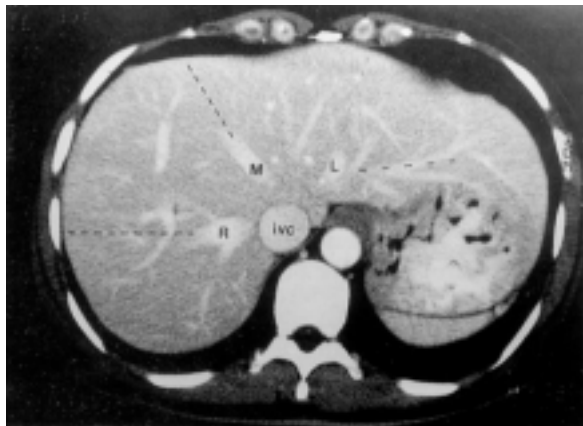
Contrast enhanced abdominal CT cut near the diaphragm, showing IVC and emerging from it the 3 main hepatic veins: right (R), middle (M) and left (L).
